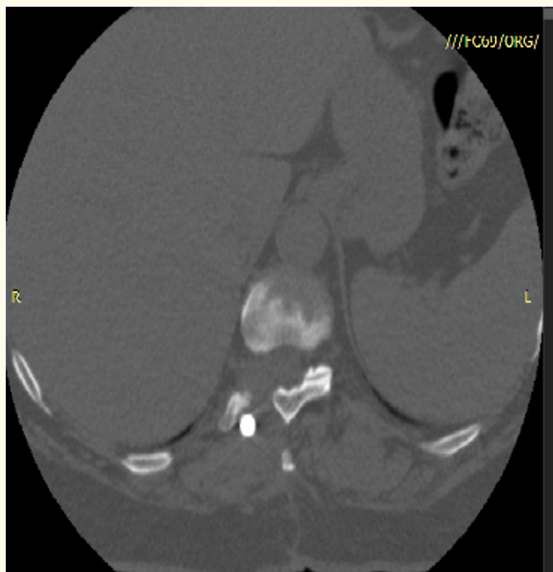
and 4B: Postoperative CT and MRI demonstrating adequate decompression of nerve root.
